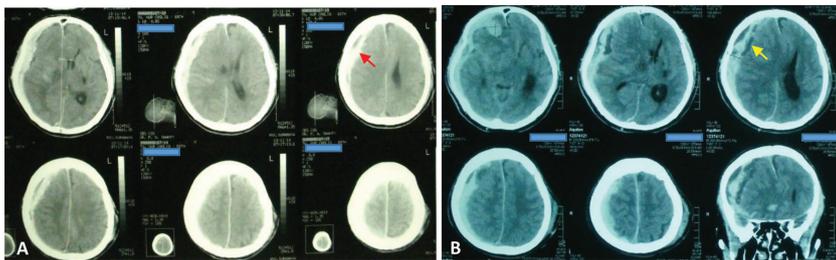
A serial non-contrast head CT of 68 years old man. A. CT Scan was taken 2 hours after the accident. Note the hyperdense lesion outside the SDH (red arrow) which indicated the bleeding was still ongoing. B. CT evaluation was taken 8 hours after admission (or 6 hours after the first CT Scan). It showed a progression of the size of the clot
